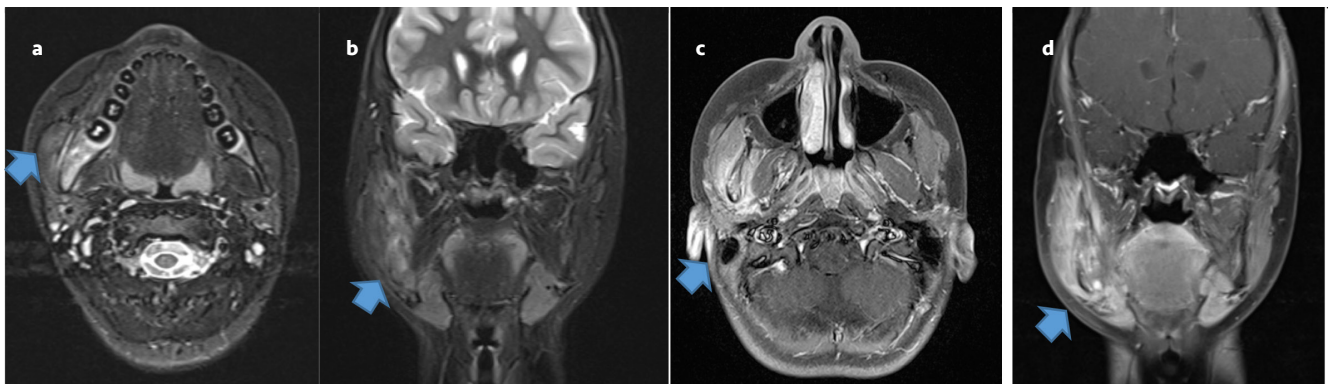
Fat-saturated T2-weighted axial (a), coronal (b) images and contrast-enhanced fat-saturated T1-weighted axial (c), coronal (d) images show bony expansion, bone marrow edema, and soft tissue inflammation adjacent to the lesion
